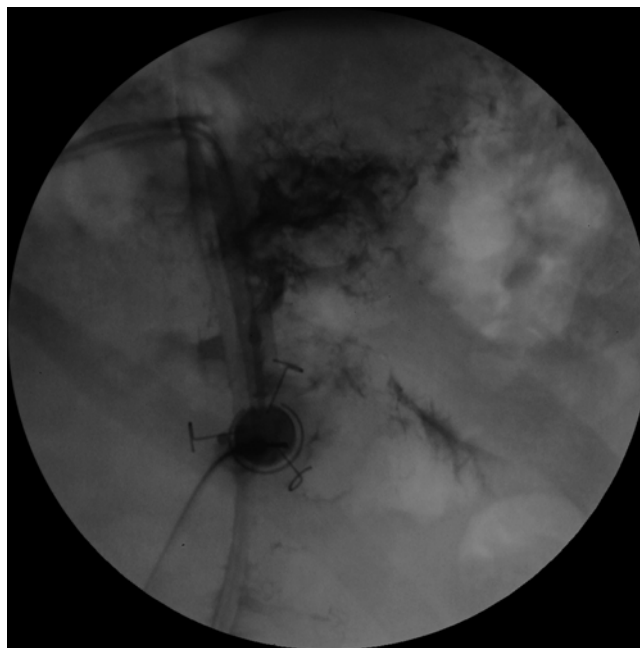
Gastric band tubing fracture resulting in leak of injected X-ray contrast
